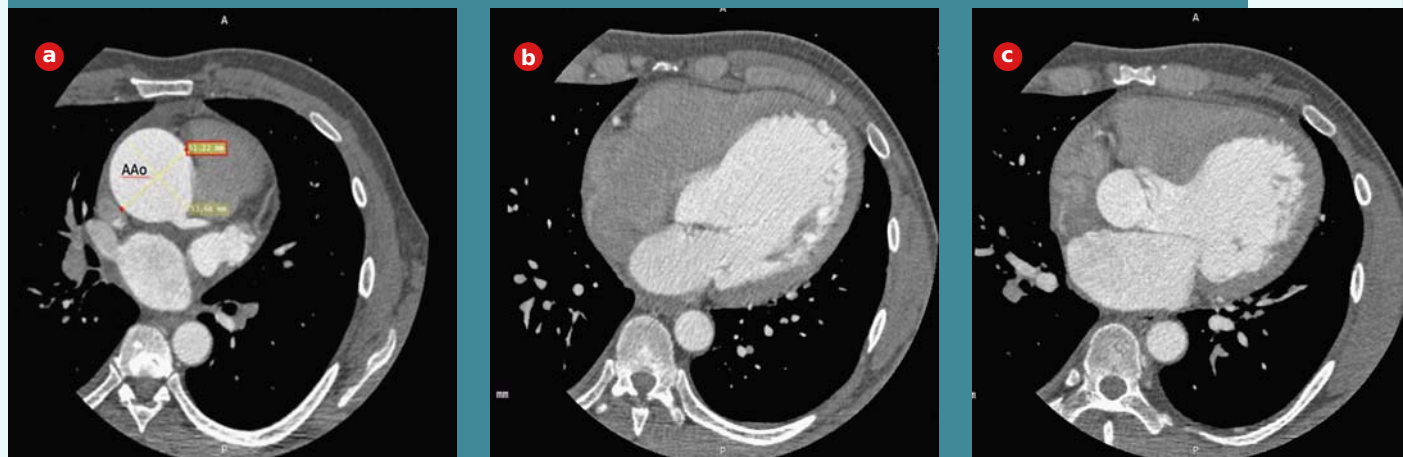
CT coronary angiogram – ascending aorta aneurysm (a); anterior mitral valve perforation (b); type I bicuspid aortic valve and filiform vegetation protruding into LVOT (c).
